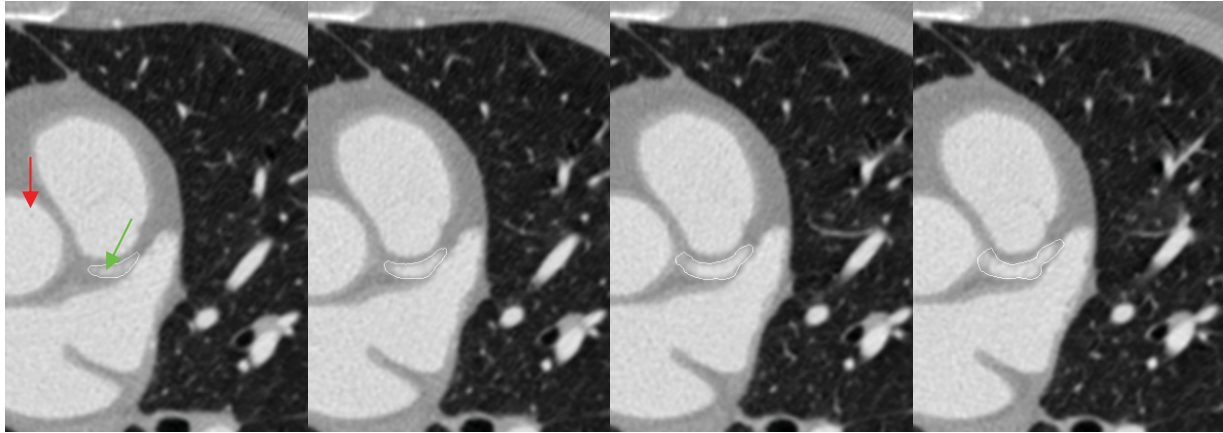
Example CT slices of the aortic root (red arrow) and the left coronary artery (green arrow). Serial slices such as these are employed in constructing the CFD model geometry.
